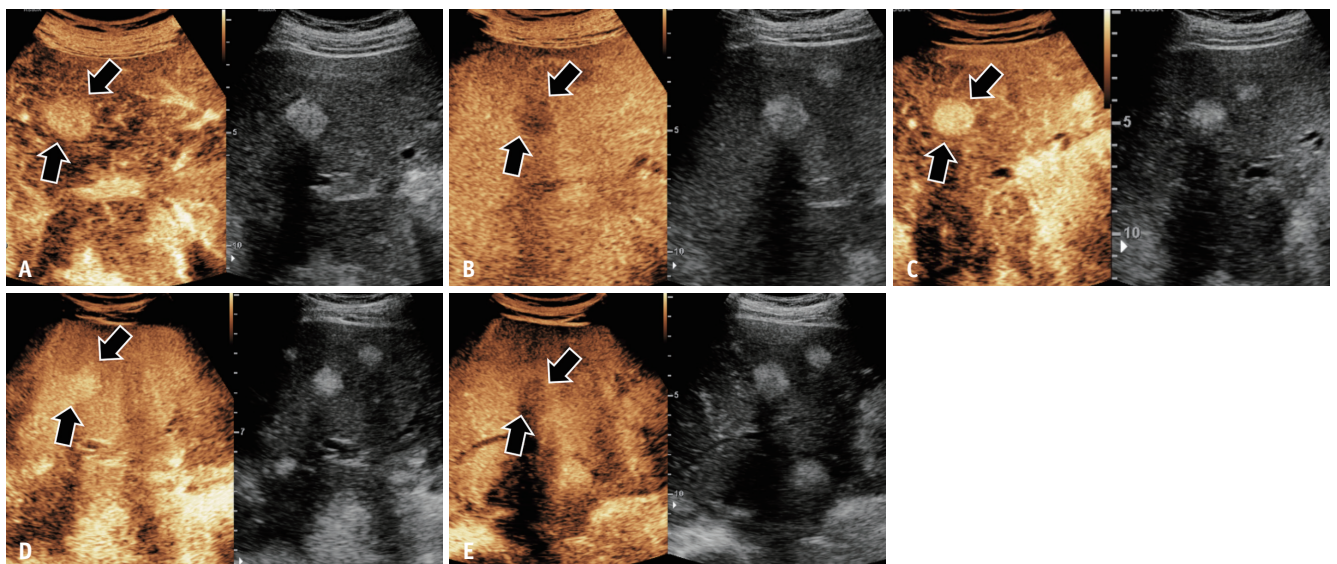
A 60-year-old female with pathologically confirmed hepatoid adenocarcinoma from the stomach in segment 6 of the liver. A, B. On SonoVue-enhanced ultrasound, a 1.9 cm APHE (A, arrows) in segment 6 presented mild washout 131 seconds after contrast agent injection (B, arrows). C-E. On Sonazoid-enhanced ultrasound, a 1.9 cm APHE (C, arrows) did not show washout until 5 minutes after contrast injection (D, arrows), and presented low echogenicity on the Kupffer phase (E, arrows). APHE = arterial phase hyperenhancement
